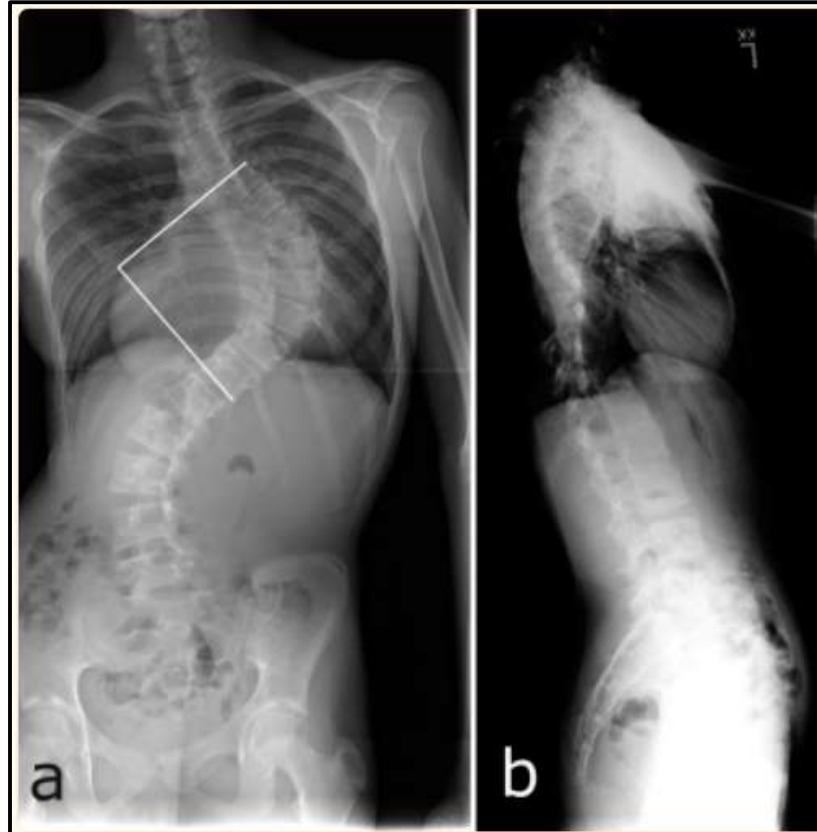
X-ray of a patient with scoliosis (7)
